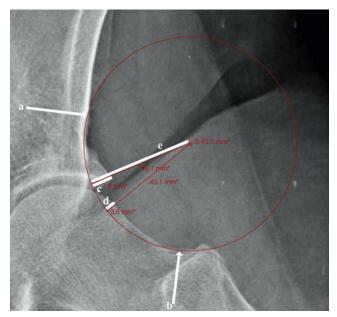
Anteroposterior pelvic radiograph demonstrating excessive pelvic tilt. As can be seen, this results in a lateralized appearance of the anteroinferior iliac spine, and an underappreciation of the pincer lesion. For this reason, the femoroacetabular impingement resection arc technique should not be used based on a radiograph with excessive tilt.
